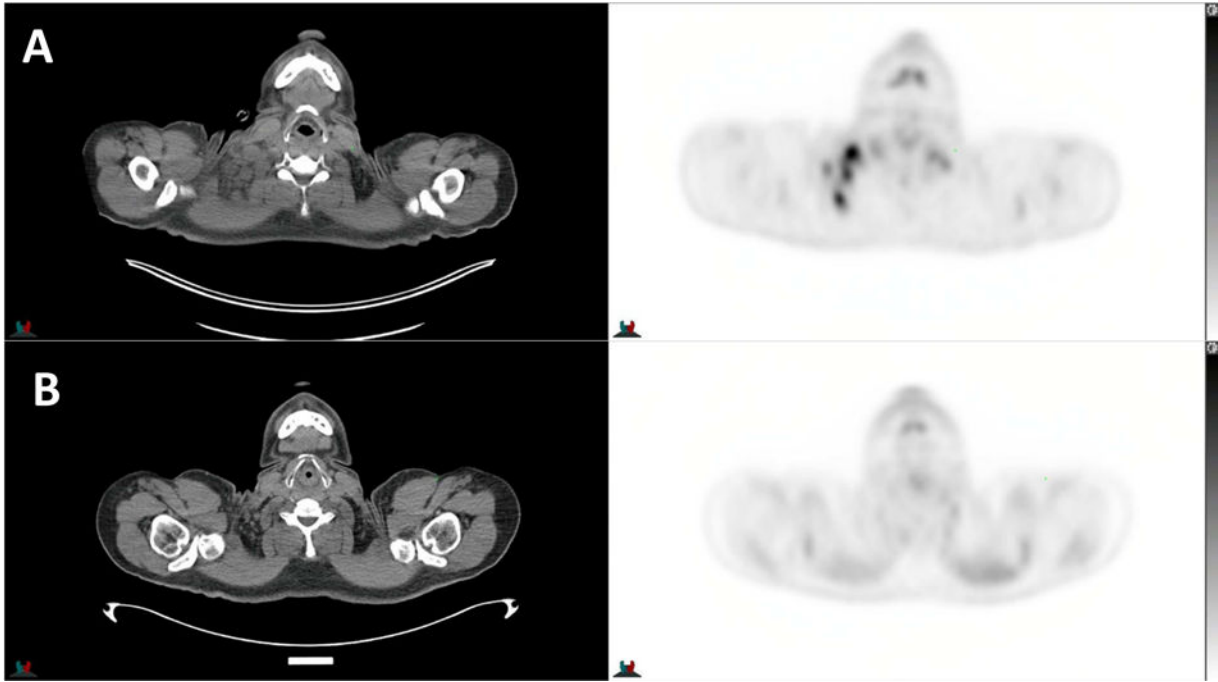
Non-contrast Computed Tomography (CT) and F-18 FDG Positron Emission Tomography (PET) Showing Lymphadenopathy Before Nivolumab (A) and Complete Resolution After Nivolumab (B)
